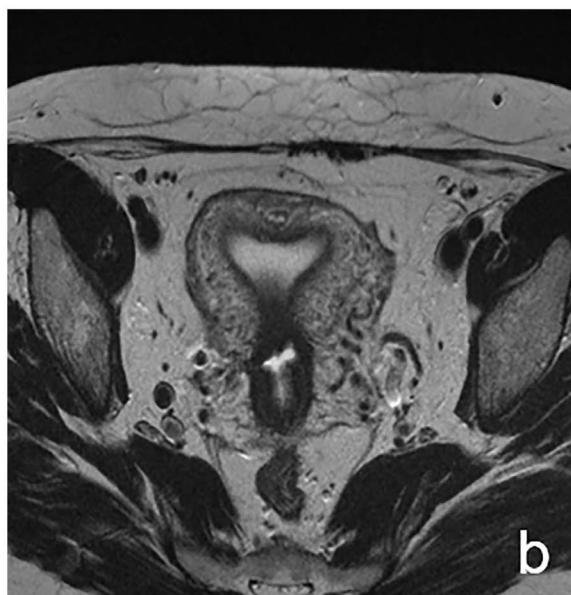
Uterine scar dehiscence: 30 y.o. patient with 2 prior cesarean deliveries and non-specific abdominal pain. Sagittal (a) and axial (b) T2-W MR images show incomplete rupture of the ventral uterine wall at the level of the old cesarean scar (white arrow), involving the myometrium but with intact overlying serosa layer. V = Fluid-filled vagina.
